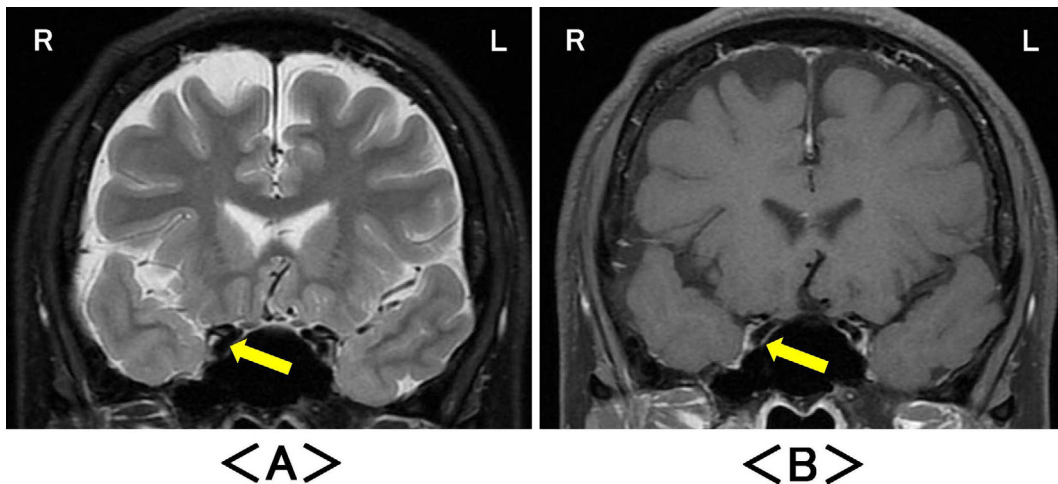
Coronal intra-orbital magnetic resonance imaging two years later revealed slight enhancement of the right oculomotor nerve on (A) fat-suppressed T2-weighted images (arrow), but (B) no abnormalities on fat-suppressed T1-weighted images with gadolinium enhancement (arrow). R: right, L: left
